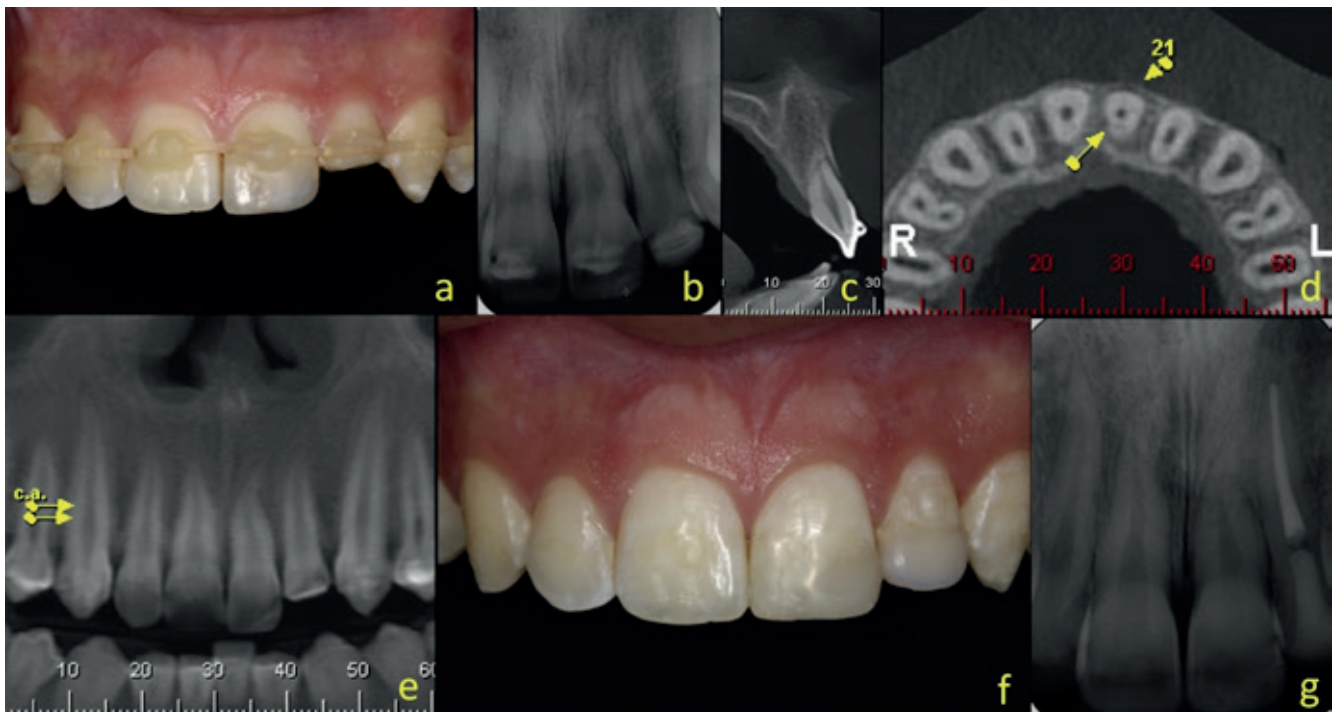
(a) Initial intraoral view of the case 3. (b) A preoperative radiograph showing horizontal root fracture at the apical third of the left maxillary central incisor. (c) CBCT showing the sagittal (d) axial (e) and panoramic view. (f) Clinical follow-up after 2-years. (g) Periapical radiograph at 2-year follow-up showing the interposition of hard tissue between the fragments.
